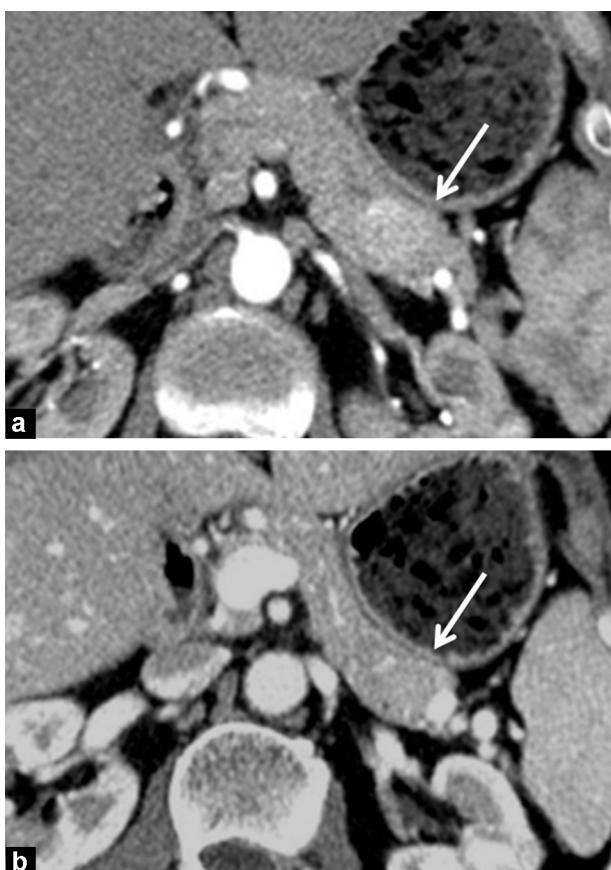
Benign insulinoma. CT images in the transverse plane during the arterial (a) and the portal venous phase (b) show a small pancreatic hypervascularized tumor of the pancreatic tail with sharp margin (arrow).
